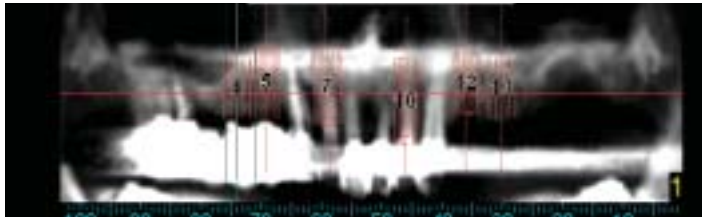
CT showing density of posterior implants
